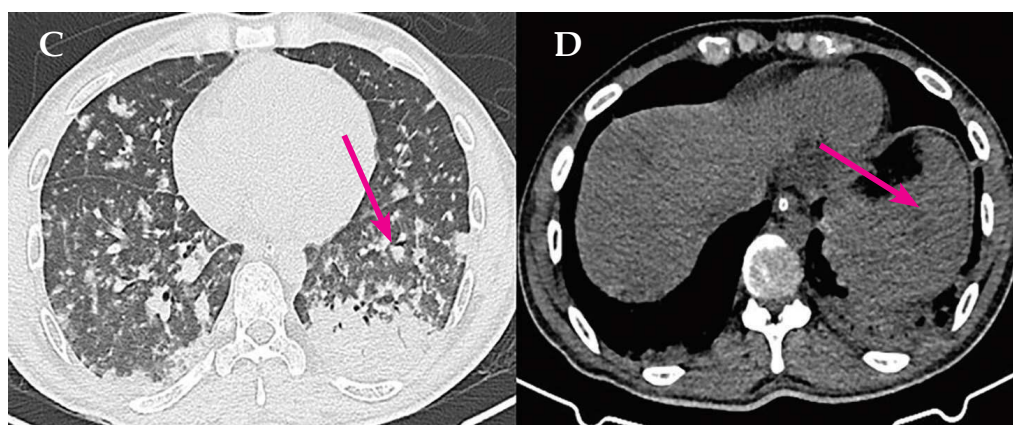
(C) CT chest showed Patchy hyperbronchial consolidations with nodules in bilateral lungs, (D) CT abdomen showed few hypodense lesions spleen suggestive of micro-abscesses
